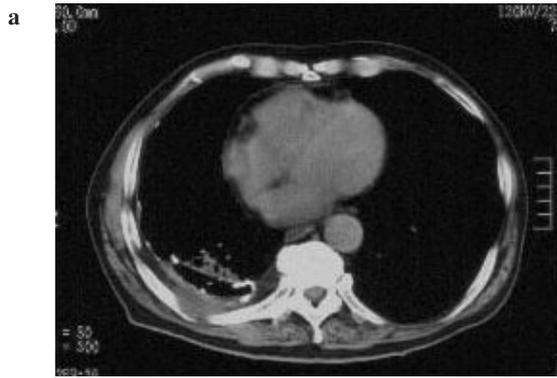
Chest CT and FDG-PET imaging performed prior to radiotherapy. (a) Plain chest CT showed the emergence of a soft-tissue attenuation mass behind the CP cavity in the right thorax 4 months after chemotherapy. (b) Coronal FDG-PET imaging revealed tumor uptake only at the back of the right thorax. Low FDG uptake due to volume loss of the lower lobe of the right lung was also seen at the left, above the tumor uptake. (c) Fusion PET and CT images revealed that FDG uptake was localized to the soft-tissue attenuation mass behind the CP cavity in the right thorax.
